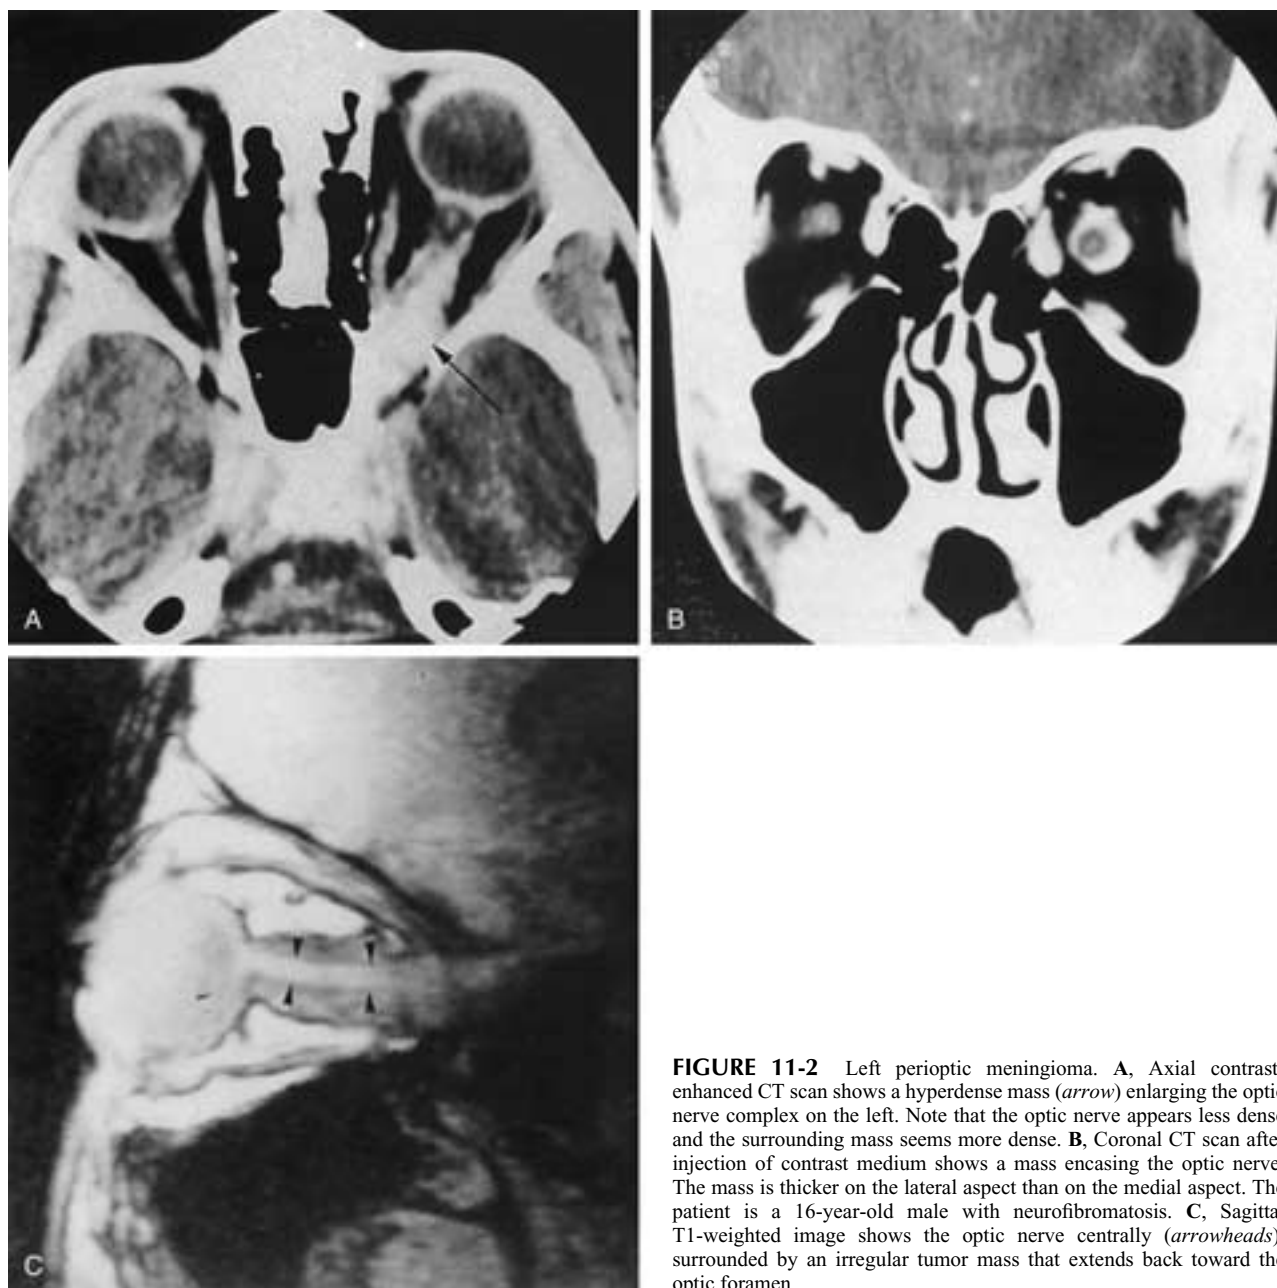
Left perioptic meningioma. A, Axial contrast-enhanced CT scan shows a hyperdense mass (*arrow*) enlarging the optic nerve complex on the left. Note that the optic nerve appears less dense and the surrounding mass seems more dense. B, Coronal CT scan after injection of contrast medium shows a mass encasing the optic nerve. The mass is thicker on the lateral aspect than on the medial aspect. The patient is a 16-year-old male with neurofibromatosis. C, Sagittal T1-weighted image shows the optic nerve centrally (*arrowheads*), surrounded by an irregular tumor mass that extends back toward the optic foramen.
